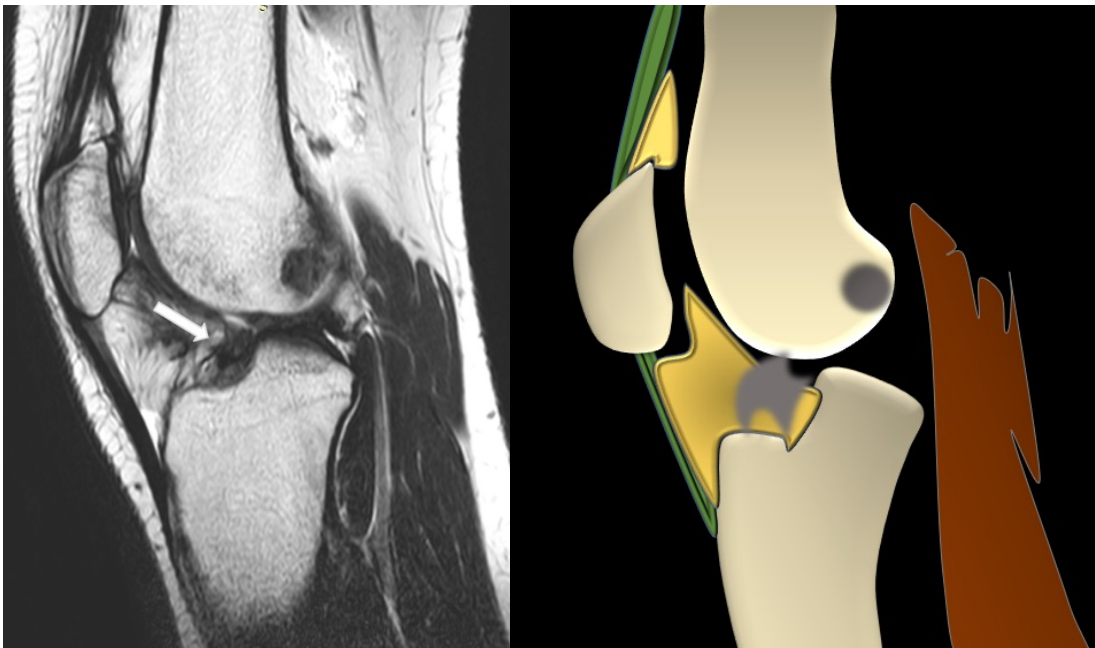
T2W sagittal MRI shows localized/focal arthrofibrosis.
